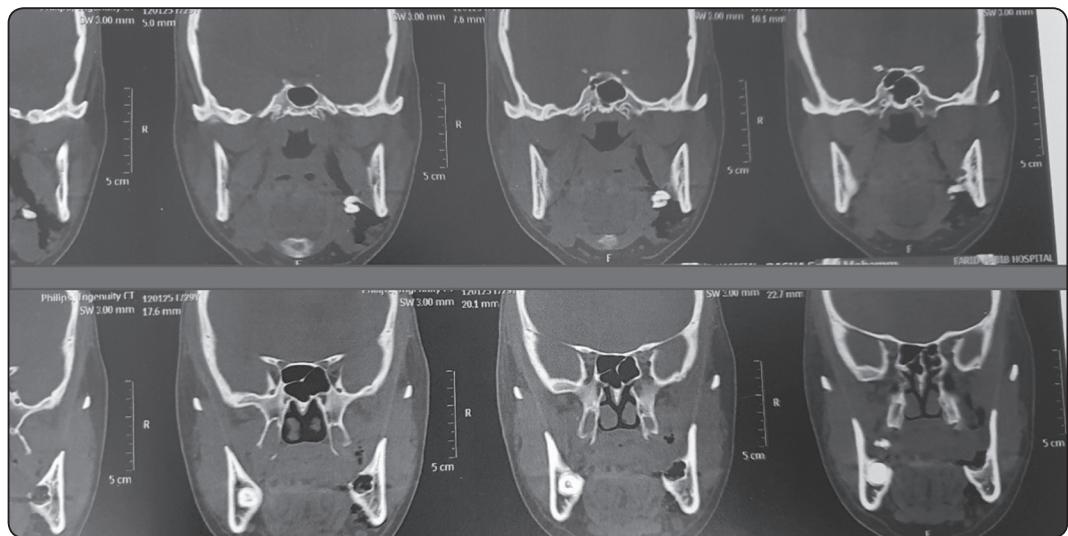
CT showing displaced third molar.
